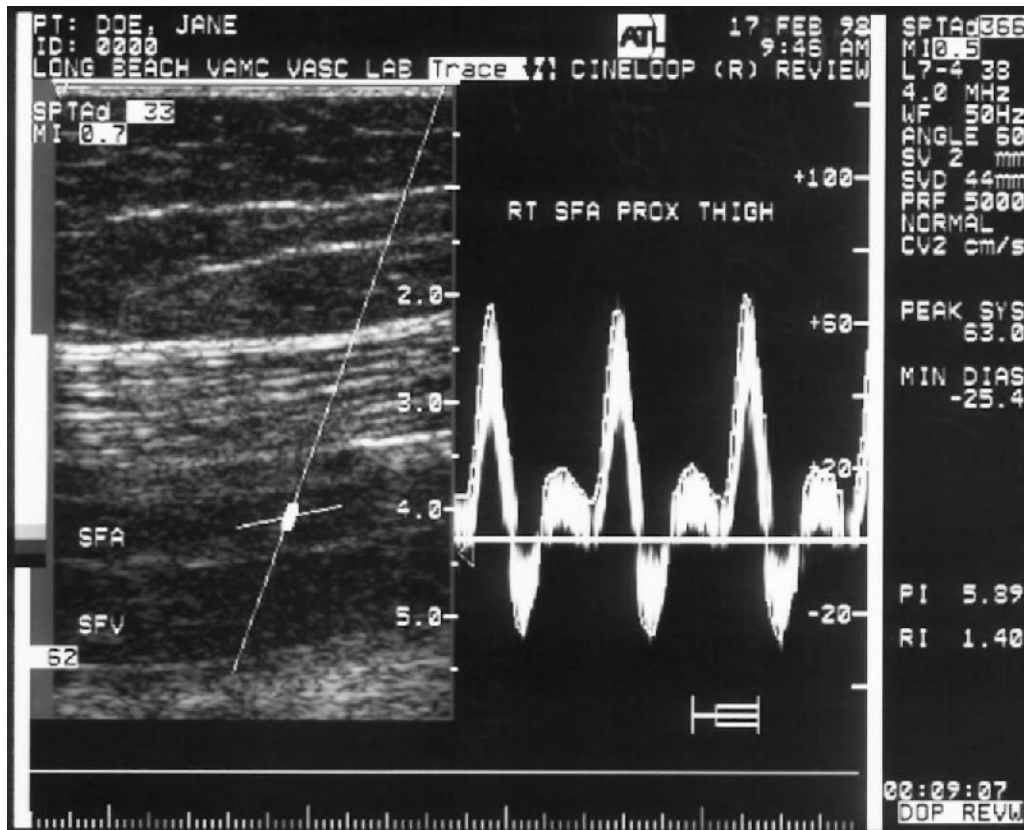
Noninvasive ultrasound. The figure shows a typical result of duplex ultrasound examination of flow in a superficial femoral artery. At the left is a gray scale image of the artery in longitudinal section, at the right is a depiction of the flow versus time waveform. Note the reversal of flow below baseline during diastole, indicating triphasic flow.
